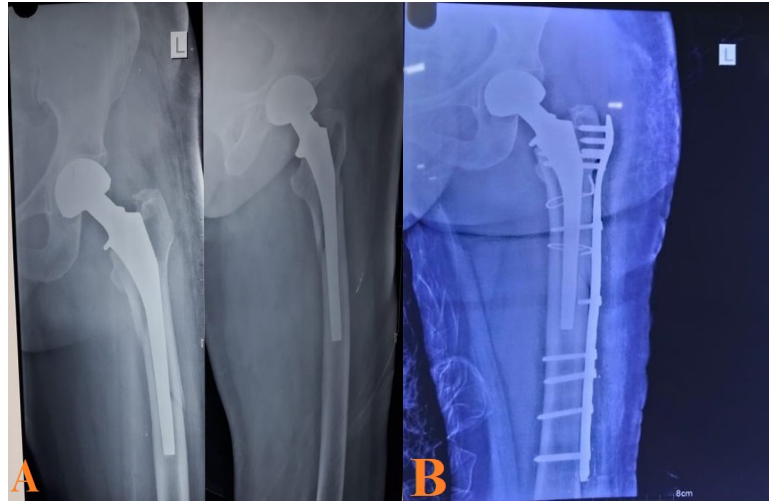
X-ray showing Vancouver B1 fracture treated by ORIF with plating and cerclages; A (pre-OP) & B (post-OP)
